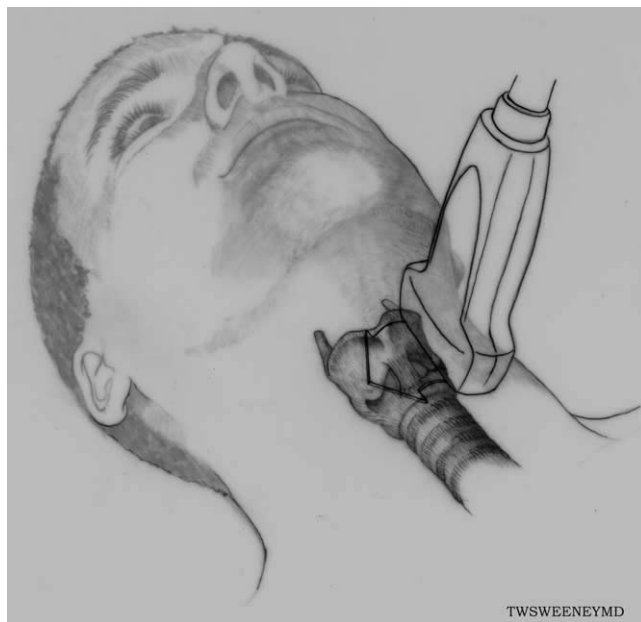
Sonographic identification of landmarks in the sagittal plane.
